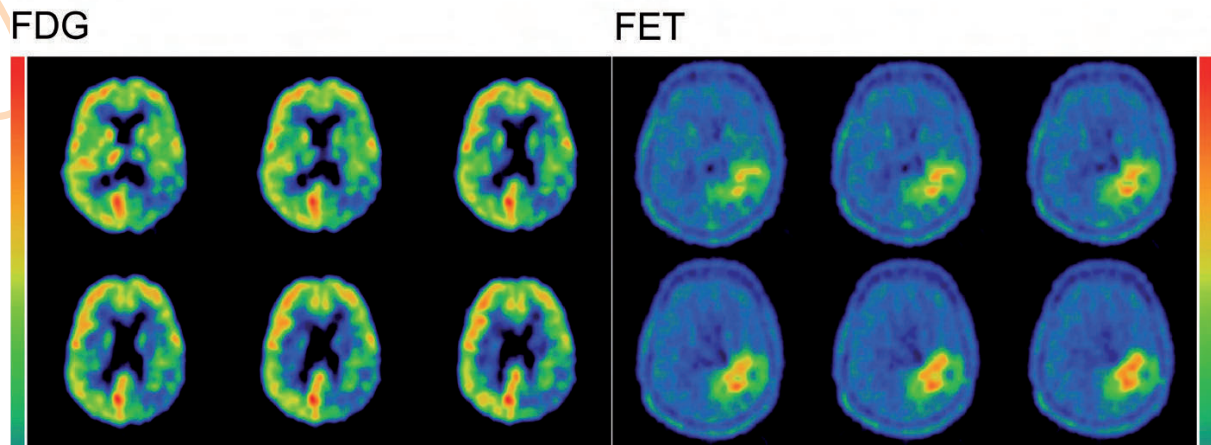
Glioblastoma: Major parts of the tumour in the left parietal lobe show  $^{18}\text{F}$ -FDG metabolism similar to or even below that of the normal cortex. There is reduced  $^{18}\text{F}$ -FDG metabolism in the surrounding oedema zone. Better delineation of the tumour borders and extent is achieved with the amino acid tracer  $^{18}\text{F}$ -FET. This may favour this type of tracer for biopsy and therapy planning
